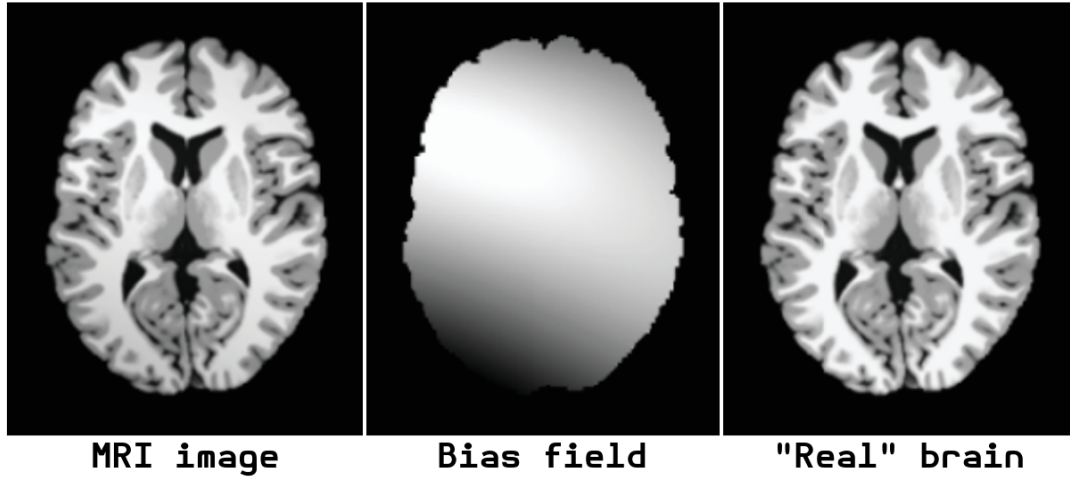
On the left we show an unprocessed MRI image. Notice how the color varies smoothly across the image due to the bias field, shown in the middle. By subtracting one from the other we obtain an image with minimal variation of pixel intensities within each structure like shown on the right.
